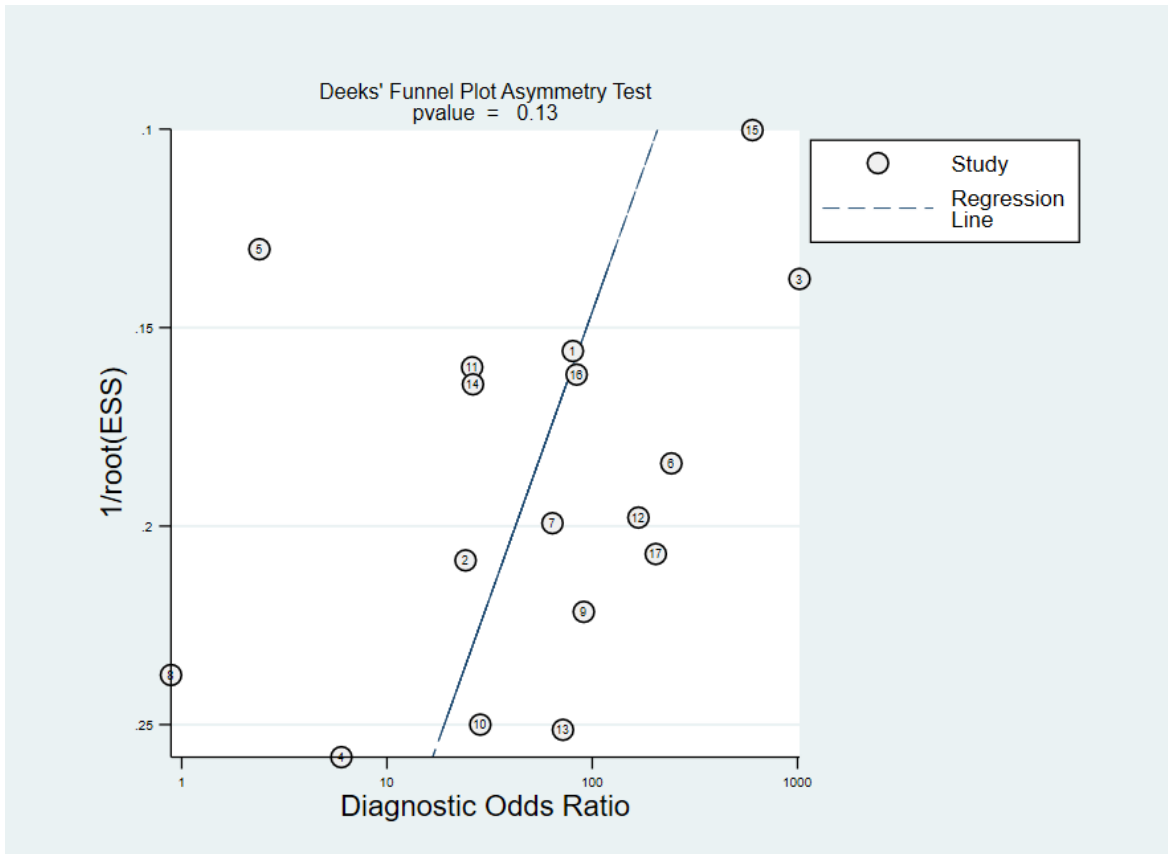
Deeks' funnel plot for publication bias of CTA diagnostic odds ratio.
